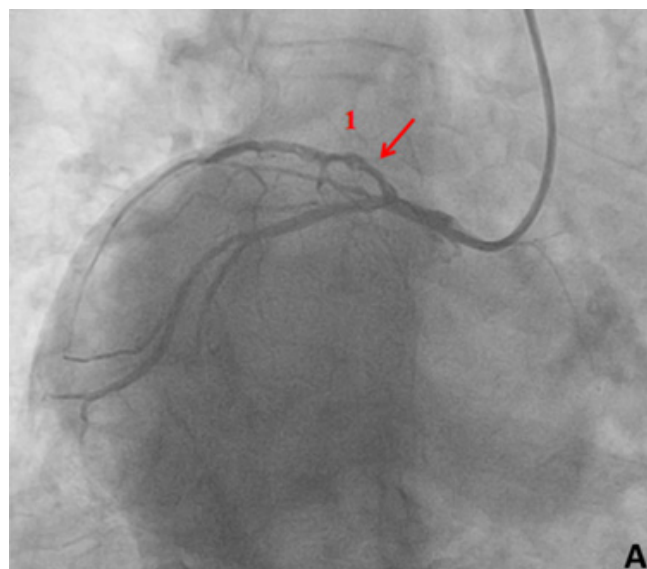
X-ray of the patient with dextrocardia
